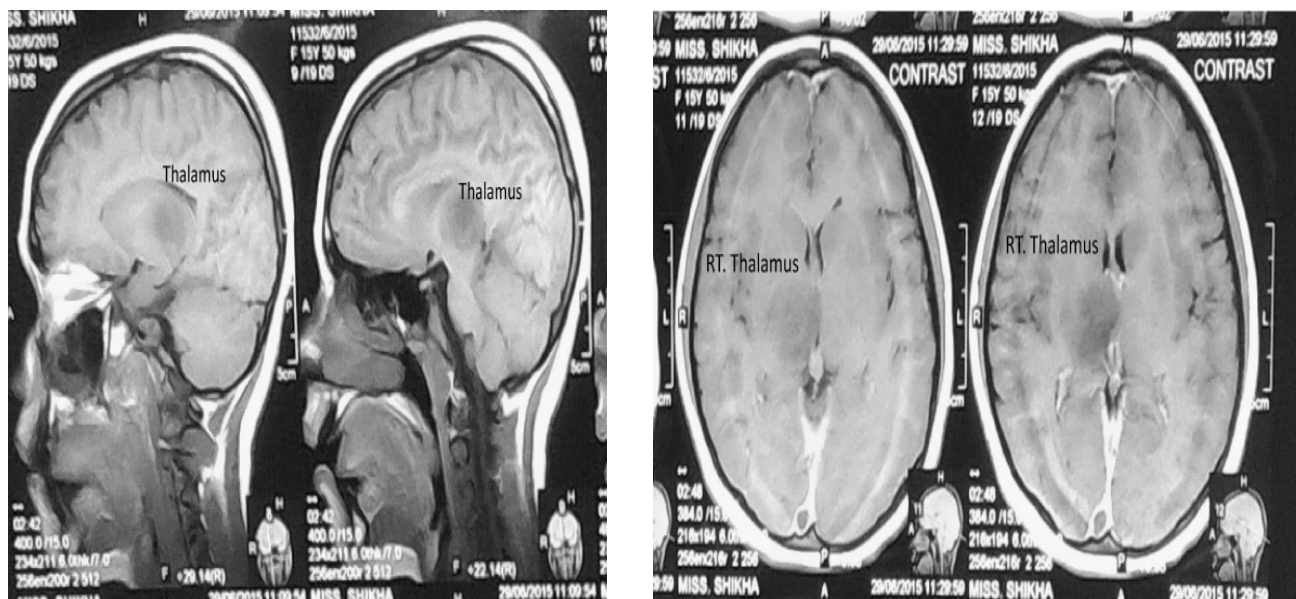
Pre-contrast sagittal and post-contrast axial T1WI MRI scan of brain. T1WI shows almost rounded altered signal area in right thalamus that is hypointense in T1WI. After I/V contrast, no abnormal enhancement is seen.
